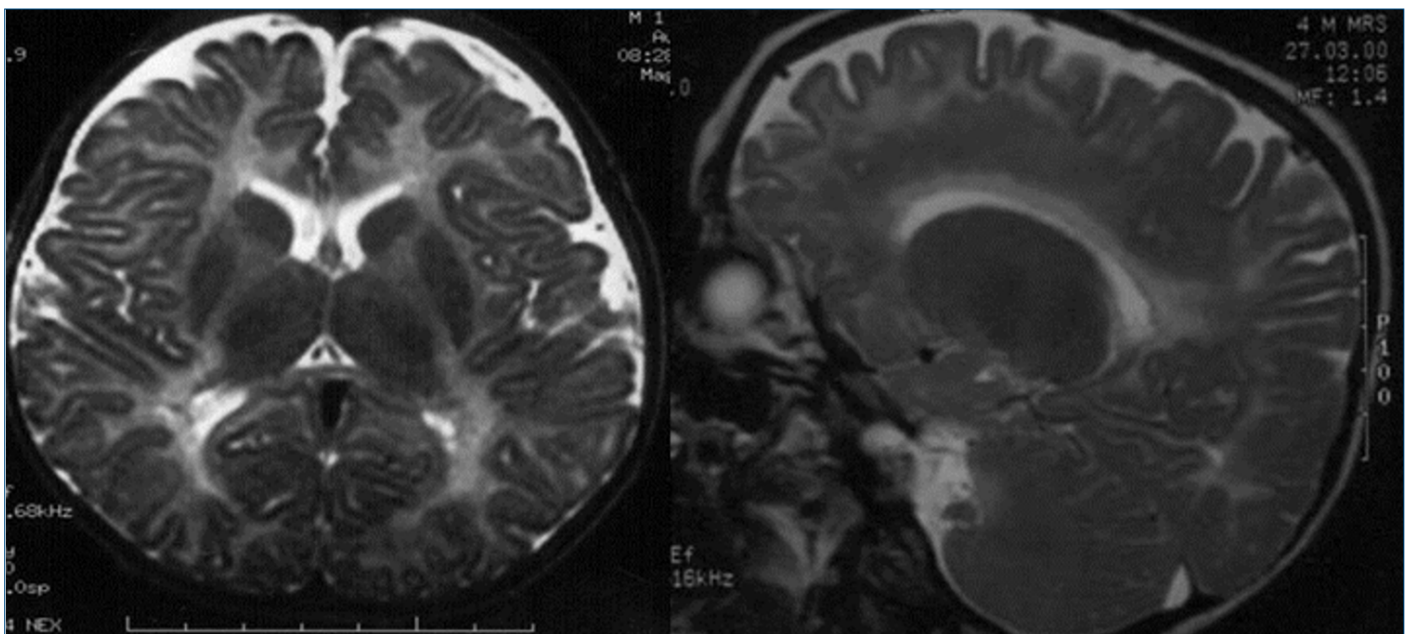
Axial and sagittal T2 cranial MRI of a PMD patient.
